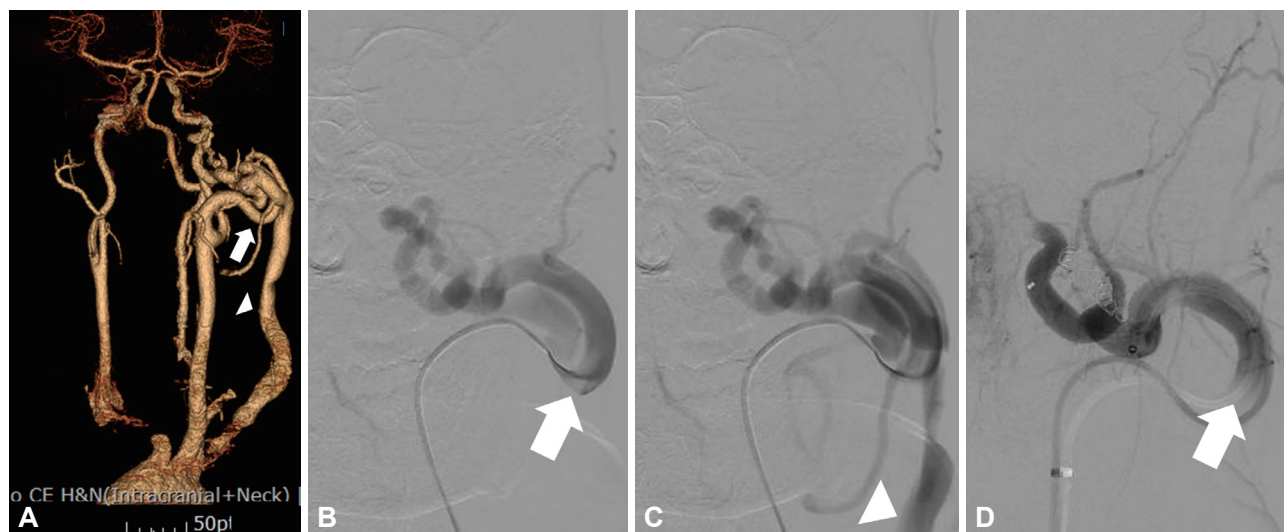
CT and conventional angiogram of the patient. A: CT angiogram of the head and neck shows enlarged left common and external carotid (arrow) arteries and left external jugular vein (arrowhead). The left external carotid artery supplies an arteriovenous fistula with venous drainage into the left external jugular vein. B and C: Early- (B) and late- (C) arterial-phase anteroposterior views from a selective external carotid angiogram show a fistula between the left external carotid artery (arrow) and the left external jugular vein (arrowhead). D: Angiogram of the same artery (arrow) after embolization shows no residual filling of the fistula.
